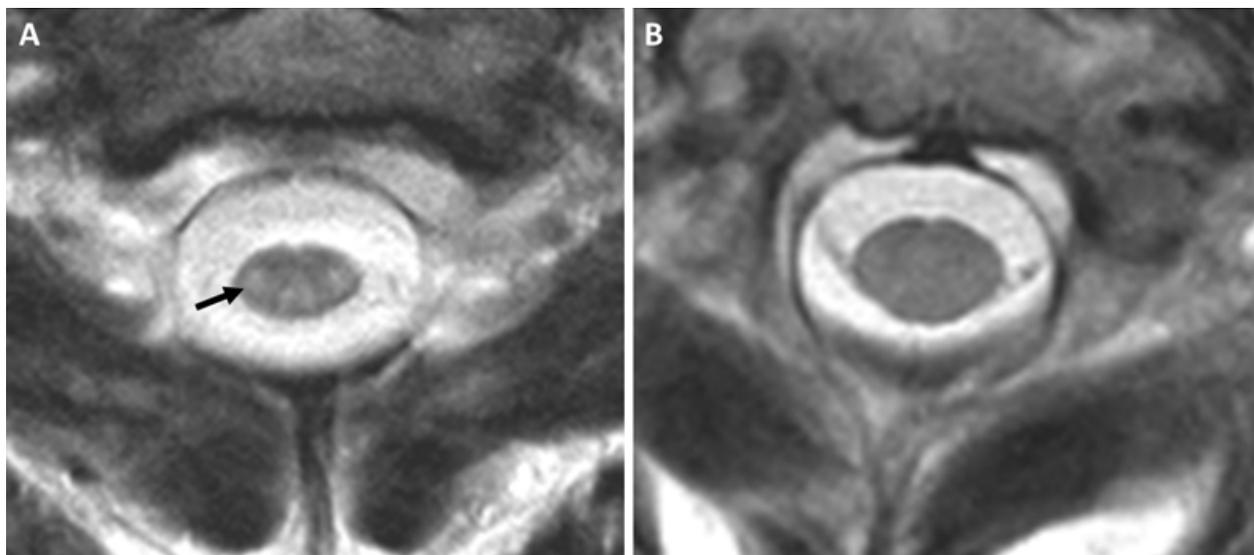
Transverse T₂-weighted spin echo MR images at the level of C II of an individual with *LMNB1*-related ADLD (A) and a healthy control (B). In the affected individual, the cross-sectional area of the spinal cord is reduced and the signal intensity of white matter is increased (black arrow).
